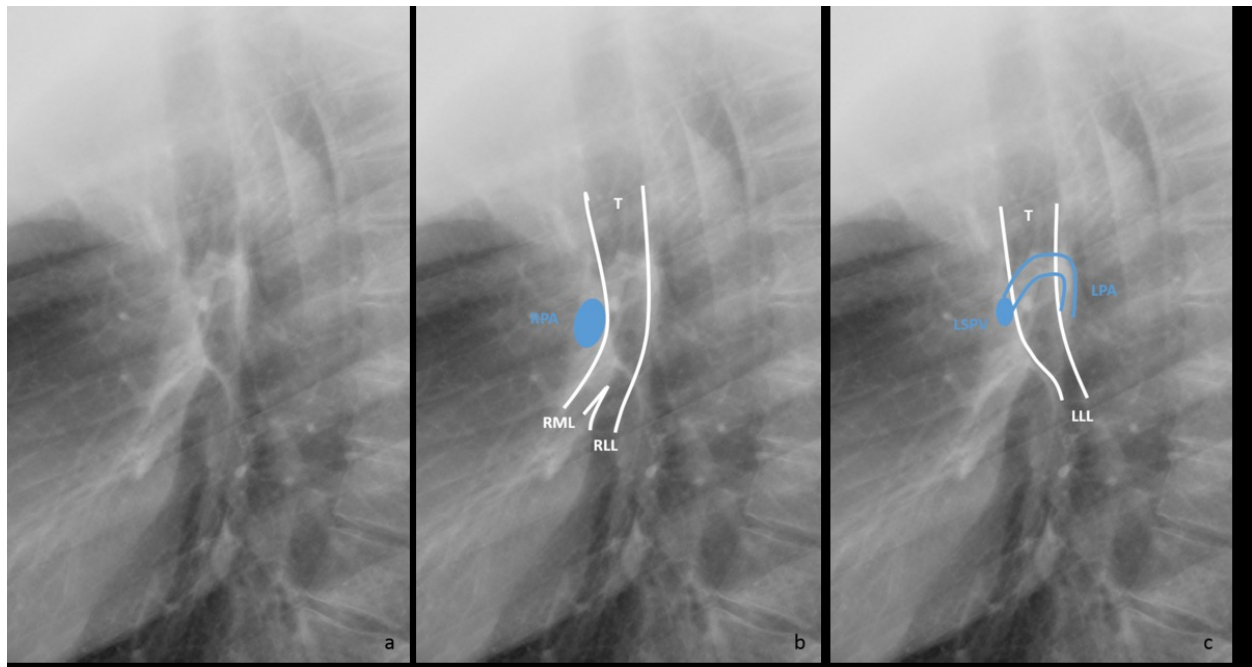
Plain left lateral radiograph demonstrating the normal hila (a) and the corresponding anatomical representation of the right hilum (b) and the left hilum (c). T: Trachea; RML: Right middle lobe bronchus; RLL: Right lower lobe bronchus; RPA: right pulmonar artery; LLL: Left lower lobe bronchus; LSPV: Left superior pulmonar vein; LPA: Left pulmonar artery.
